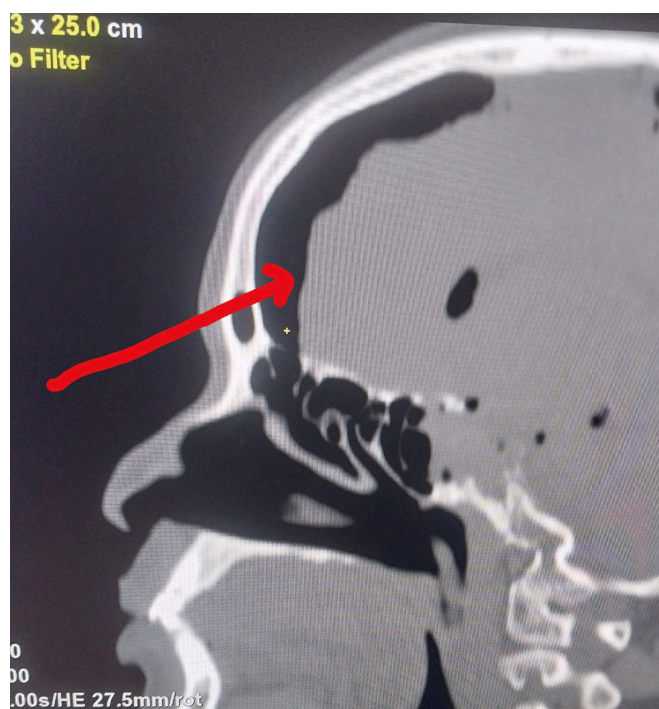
CT scan sagittal view of massive pneumocephalus (Credit: Dr Justin Rubena Luamaya)
